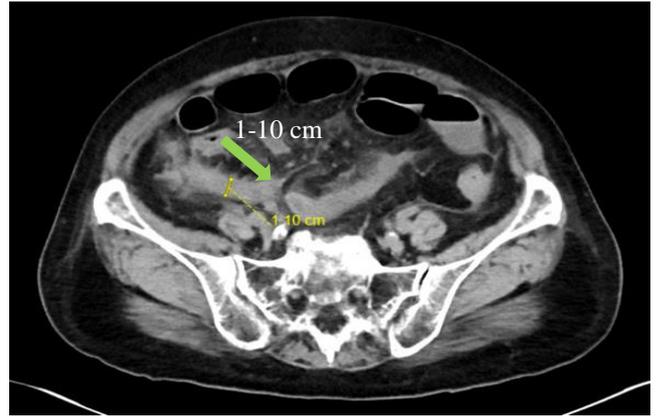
CT image on admission, axial; appendix and peri appendiceal inflammatory changes.
